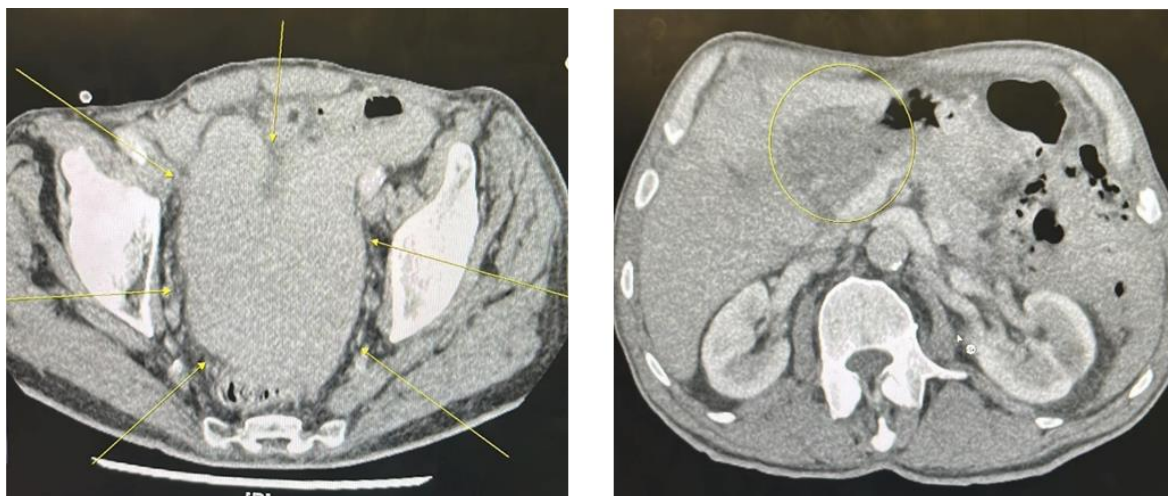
CT scan revealing a clearly demarcated dense liquid collection with a density of 62 HU confirming an organised haemorrhage collection
